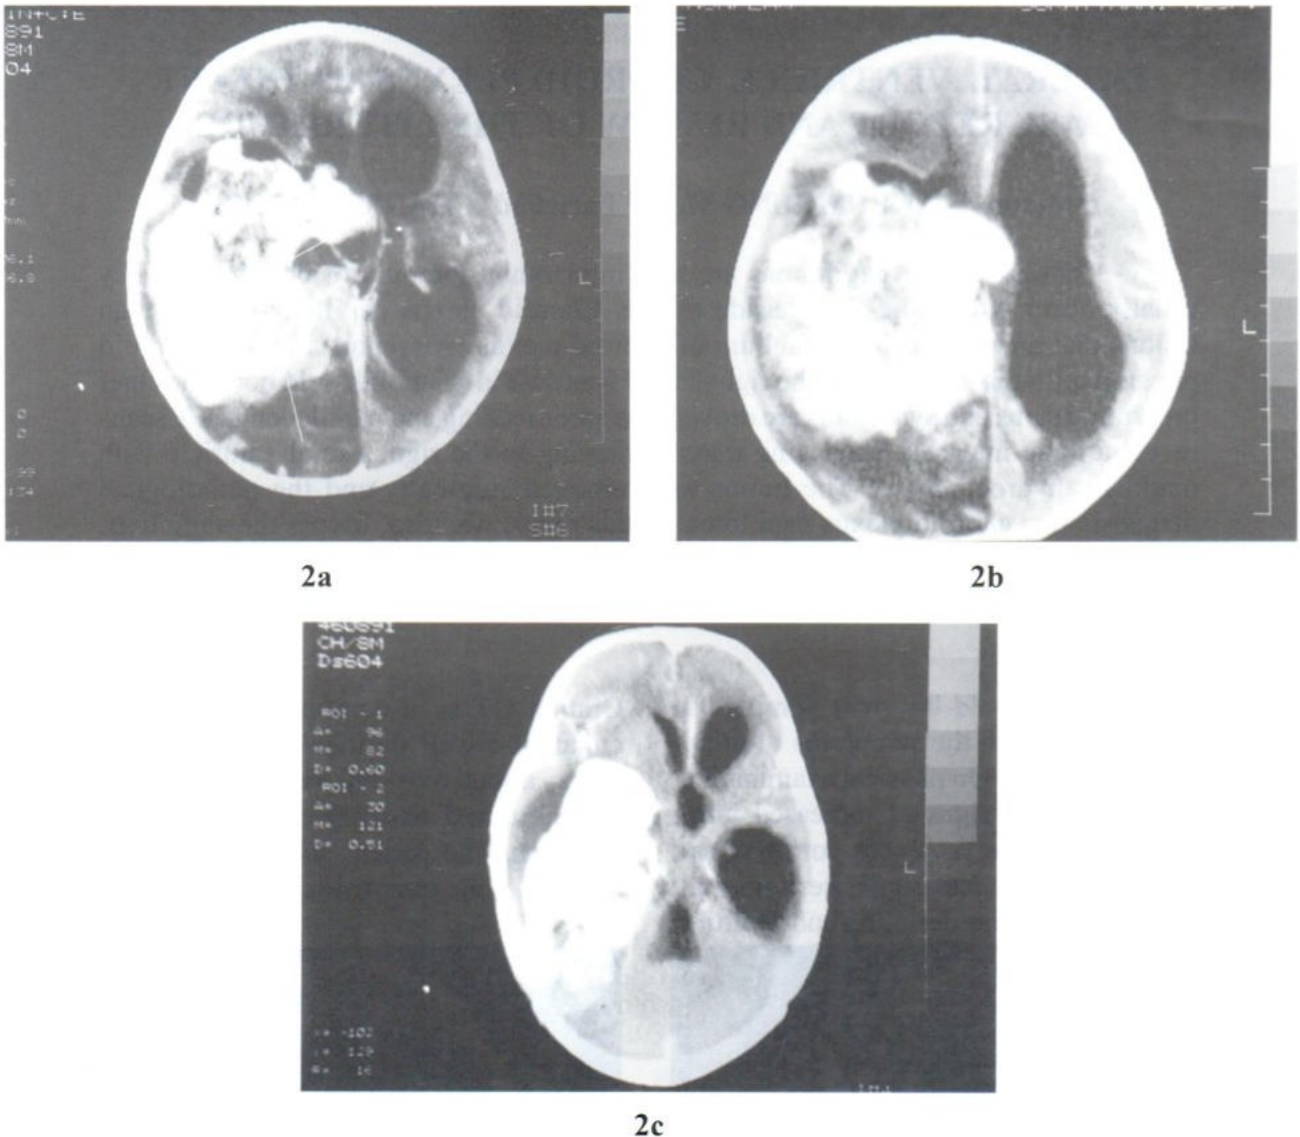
Contrast CT shows intense enhancing mass in the Rt. lateral ventricle
